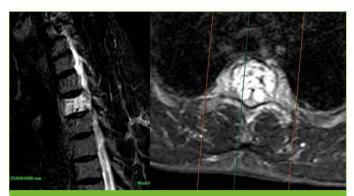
Preoperative contrast MRI showing extension of the lesion into the spinal canal and no involvement of posterior element
